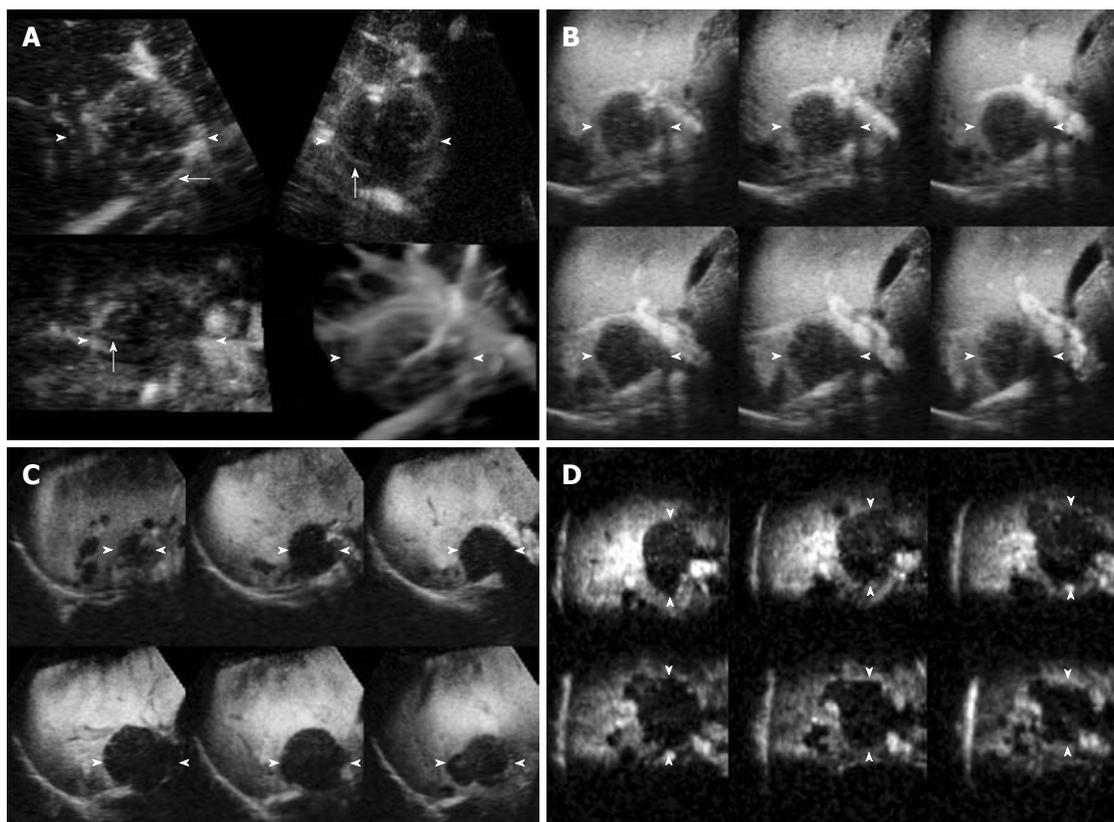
CE 3D US images of the liver in a 64-year-old woman with metastases from pancreatic carcinoma in the anterior superior segment of the right lobe. A: Images in the early phase show peripheral ring-like enhancement with peritumoral vessels (arrows) in plane A (upper left), plane B (upper right), plane C (lower left) and the sonographic angiogram rendered by average intensity with surface mode (lower right); B: Tomographic ultrasound image with slice distance 2.0 mm in plane A shows peripheral ring-like enhancement in the middle phase; C, D: Tomographic ultrasound images (TUI) in plane A with slice distance 2.5 mm (C) and that in plane C with slice distance 2.0 mm (D) show hypoechoic pattern in the late phase. Enhancement change of washout was detected in this lesion. Arrowheads indicate the tumor margin.
